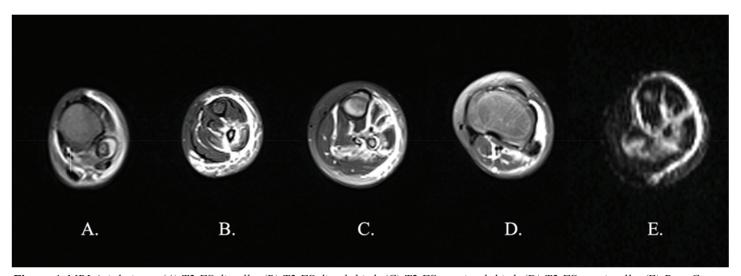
MRI Axial views. (A) T2 FS distally, (B) T2 FS distal third, (C) T2 FS proximal third, (D) T2 FS proximally, (E) Post Contrast middle of leg.
